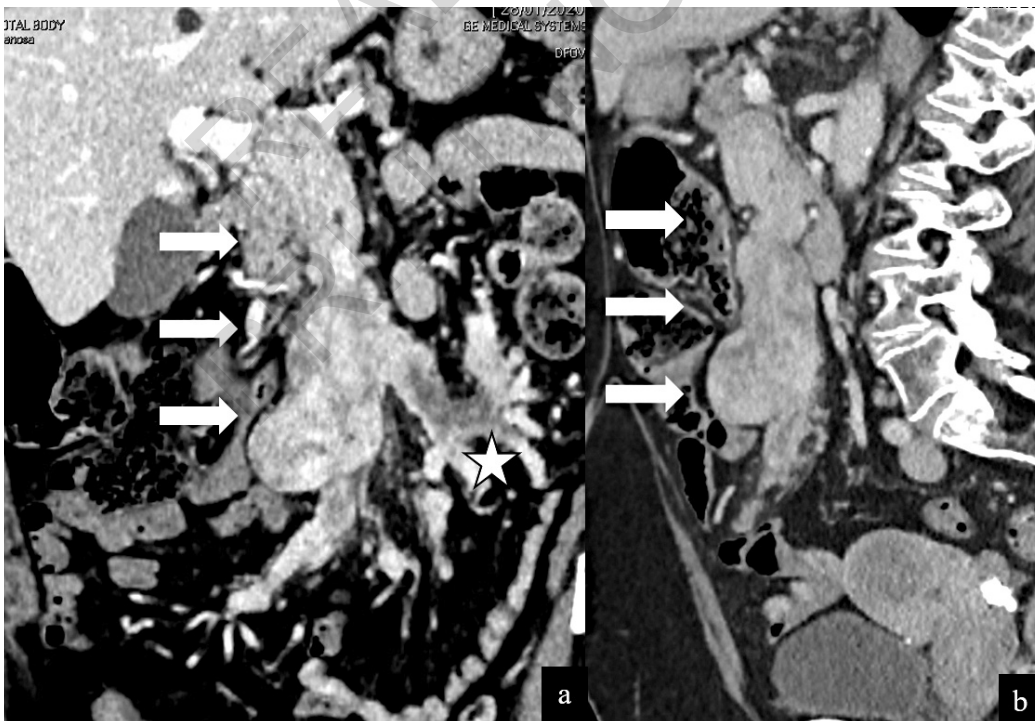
Leiomyosarcoma of the superior mesenteric vein. Coronal (a) and MIP sagittal (b) contrast enhanced CT images reveal an heterogeneous mass developing along the superior mesenteric vein (arrows), causing thrombosis (asterisk).
